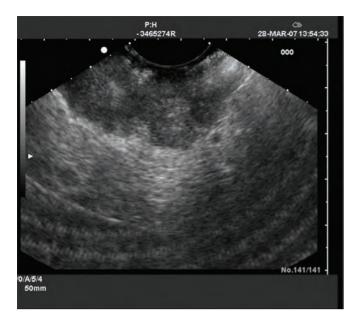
Endosonography of a gastric cancer.
